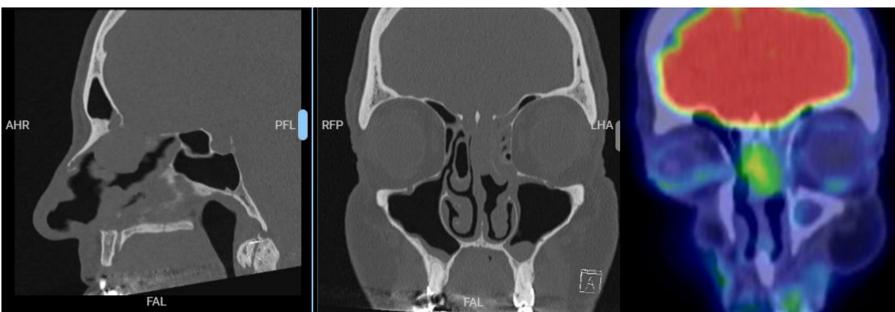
Preoperative CT and PET
